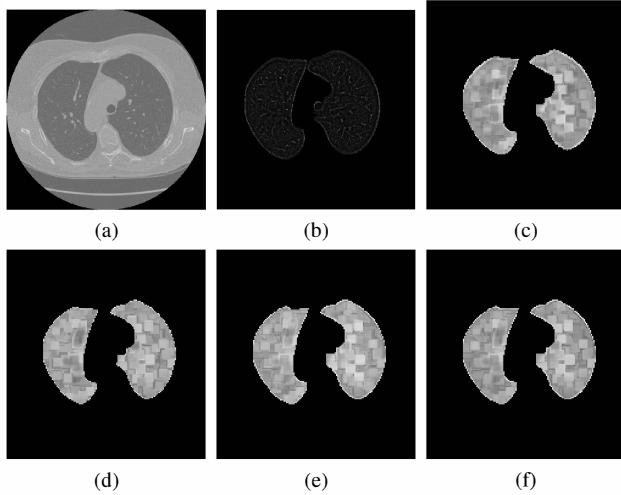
The examples of processed CT image. a) original CT image; b) RX-algorithm output; c) kernel RX-algorithm output with N_L neighborhood; d) kernel RX-algorithm output with N_P neighborhood; e) kernel RX-algorithm output with N_C neighborhood; f) kernel RX-algorithm output with N_M neighborhood;
